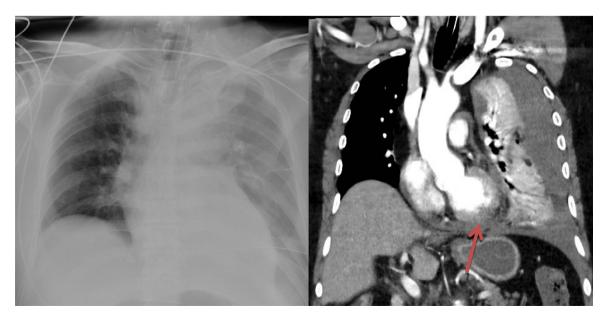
Chest X-ray and coronal CT image. Extensive hemothorax and atelectasis on the left side. Extensive hemopericardium is seen on the CT image on the right side.
